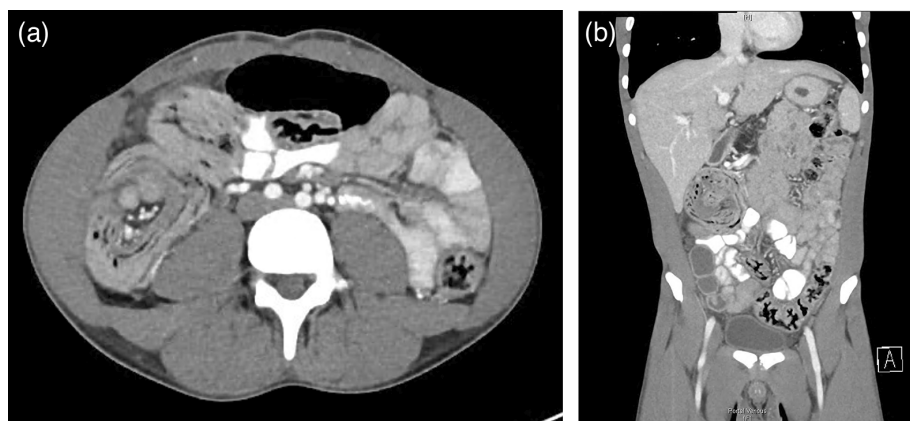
Intussusception (CT). A computerized tomography of the abdomen & pelvis with IV contrast in the portal venous phase, showing intussusception of the caecum, appendix, and distal ileum into the ascending colon without an identified lead point. (a: Axial view, b: coronal view).
